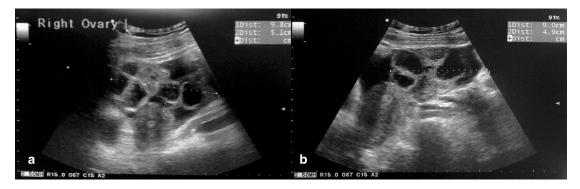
Trans-abdominal ultrasound. (a) Enlarged right ovary (9.8×5.1 cm). (b) Enlarged left ovary (9.0×4.9 cm) with ascites.
